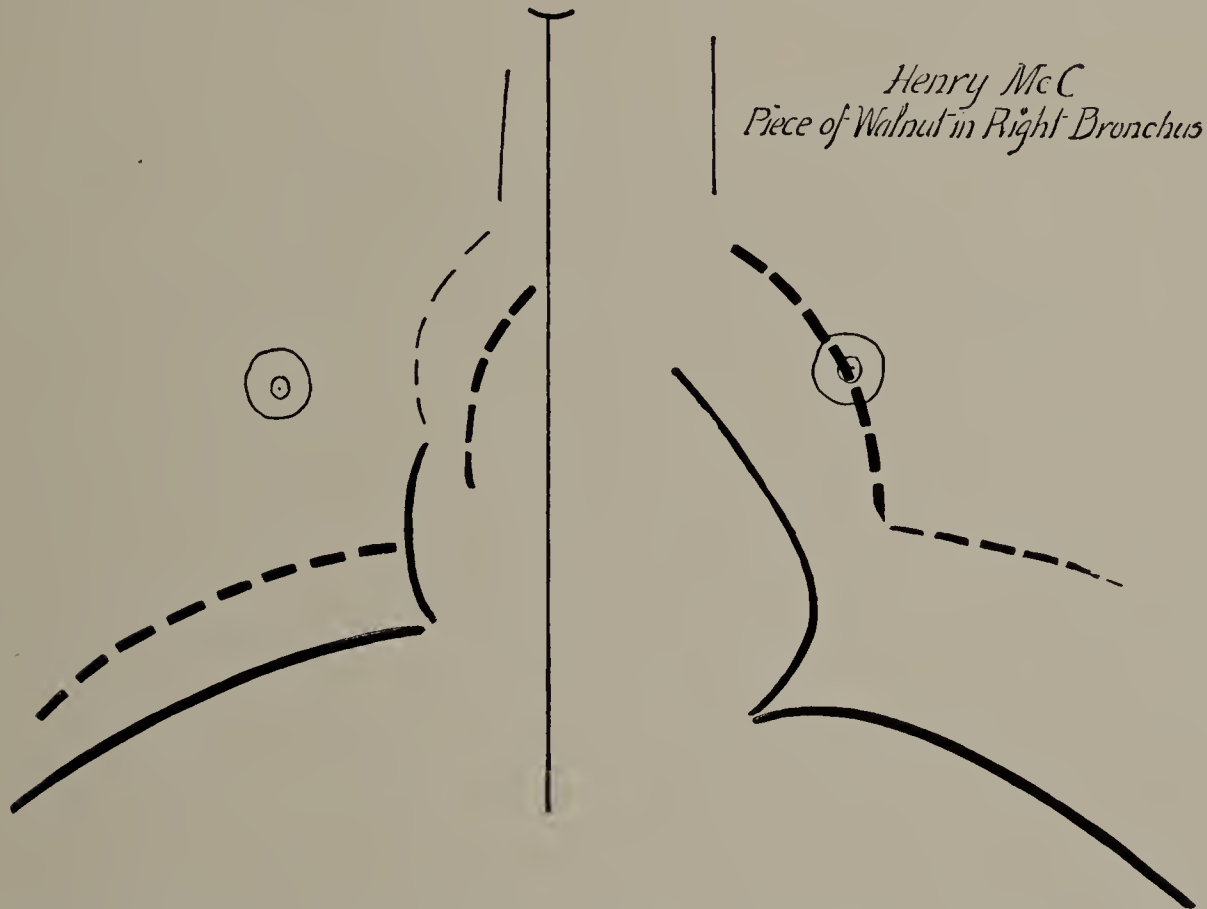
Henry McC. November 7, 1899. X-ray examination with screen before removal of walnut shell; excursion of diaphragm shortened on right side.
